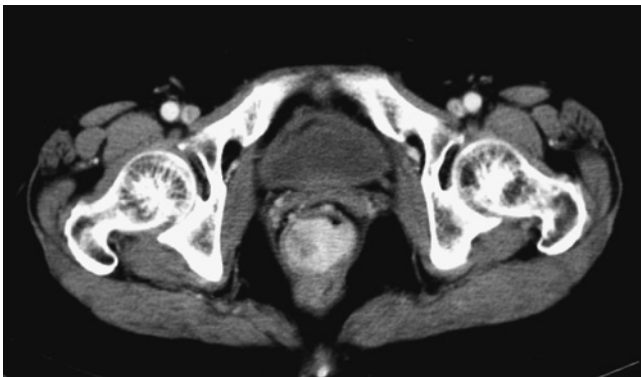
Abdominal contrast computed tomography scan. A 20-mm tumor with contrast enhancement is visible in the rectal canal.
